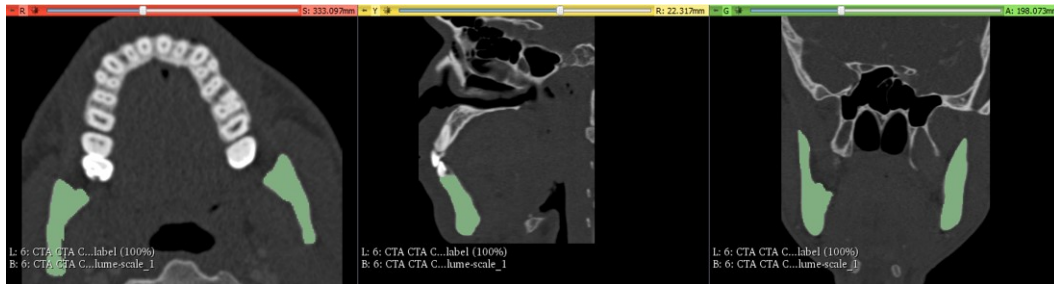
Snapshot of patient CT scan with mandible isolated
